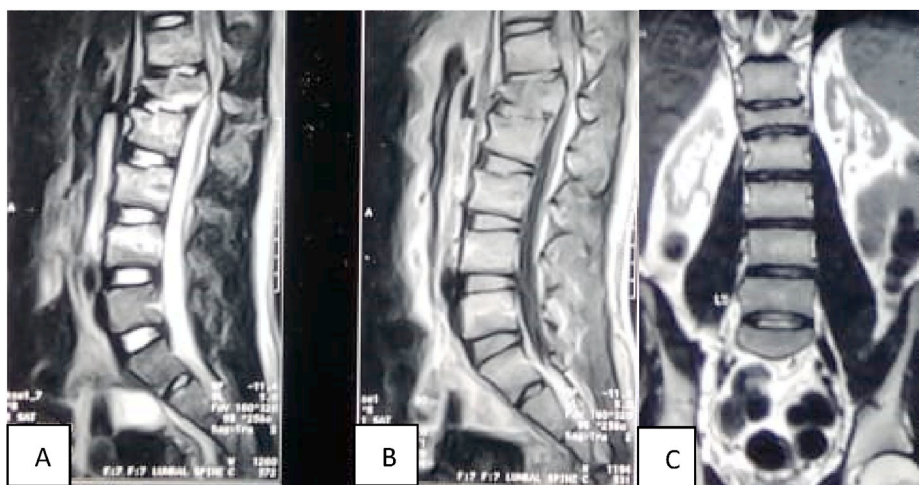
MRI examination on patient revealed spinal cord injury.
